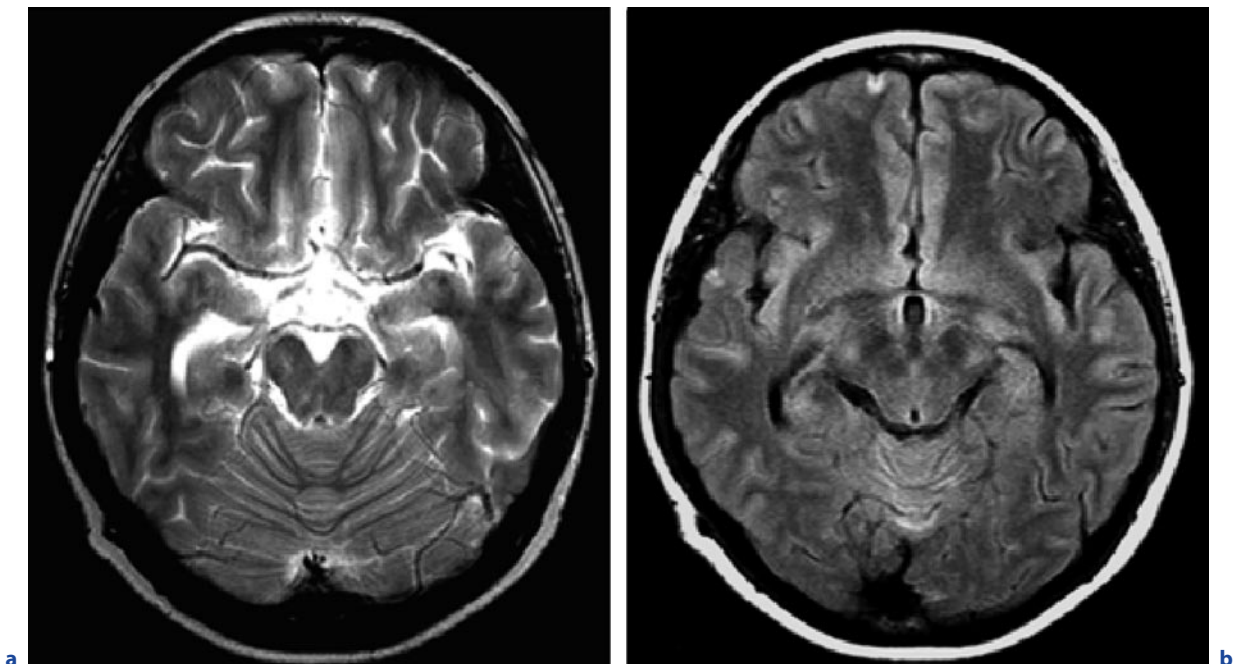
Cryptococcal leptomeningitis. a Axial T2-weighted image. b Axial FLAIR images. c–f see next page
